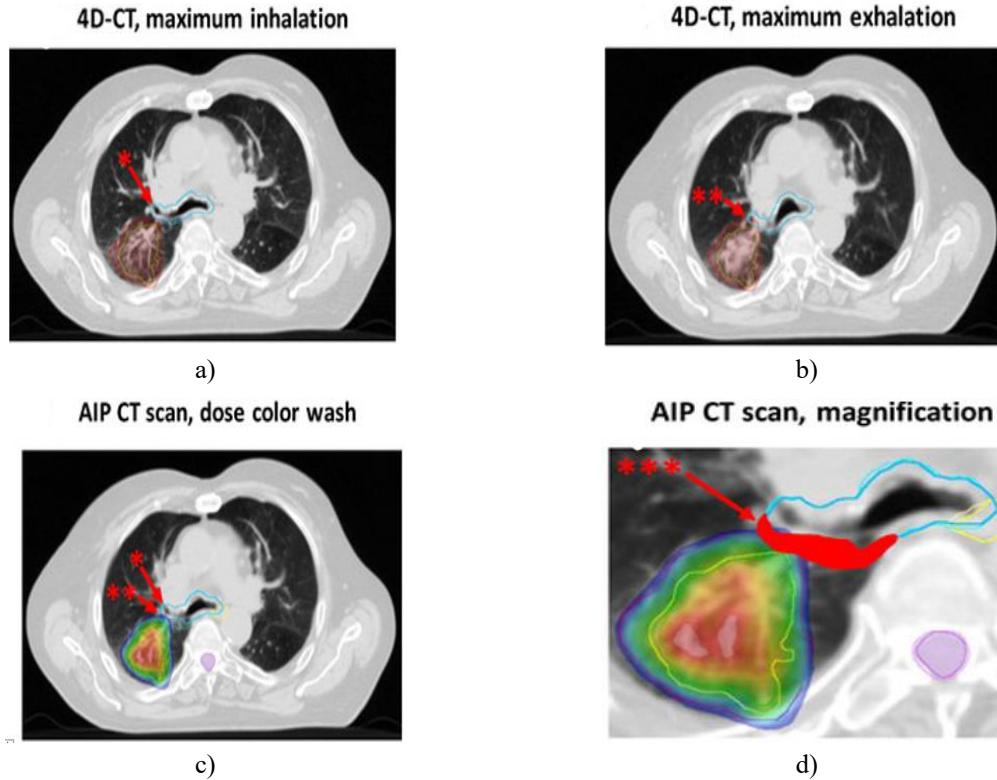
Visualization of breathing-related bronchial tree motion for a patient with stage IIA right-upper-lobe adenocarcinoma. SBRT was delivered as 60 Gy in 8 fractions to the 80% isodose using VMAT. Panels A and B show the 4D-CT slices at maximal inspiration and expiration. Panel C (AIP CT) displays the 60-75 Gy dose region (blue to red) along with bronchial tree contours (turquoise). Panel D magnifies the OAR-IRV volume difference. The GTV lay 3 mm from the bronchial tree. The bronchial tree volume measured 59.0 cm³, compared with an IRV of 94.4 cm³ (a 35.5 cm³ increase; +60%). The maximum centroid shift between the two structures was 10.1 mm. Dmax increased by 8.4 Gy (62.9 Gy for the OAR vs. 71.2 Gy for the IRV). The rise in NTCP was 11.5% (relative increase 44.2%).
